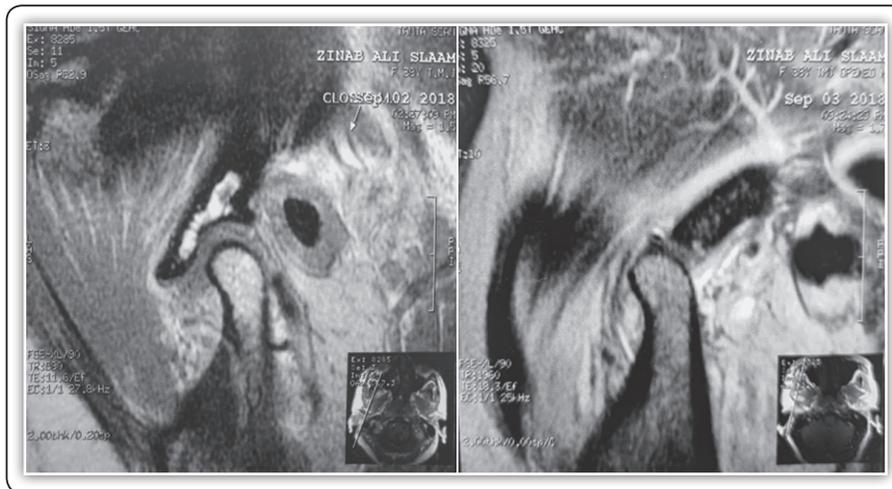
(left) Preoperative MRI closed Position, (Right): Preoperative MRI Open position
